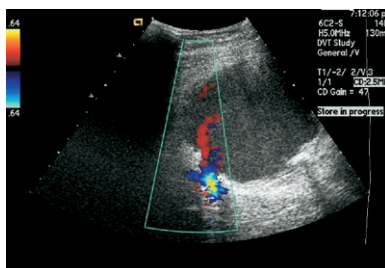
Doppler ultrasonography of mass.
